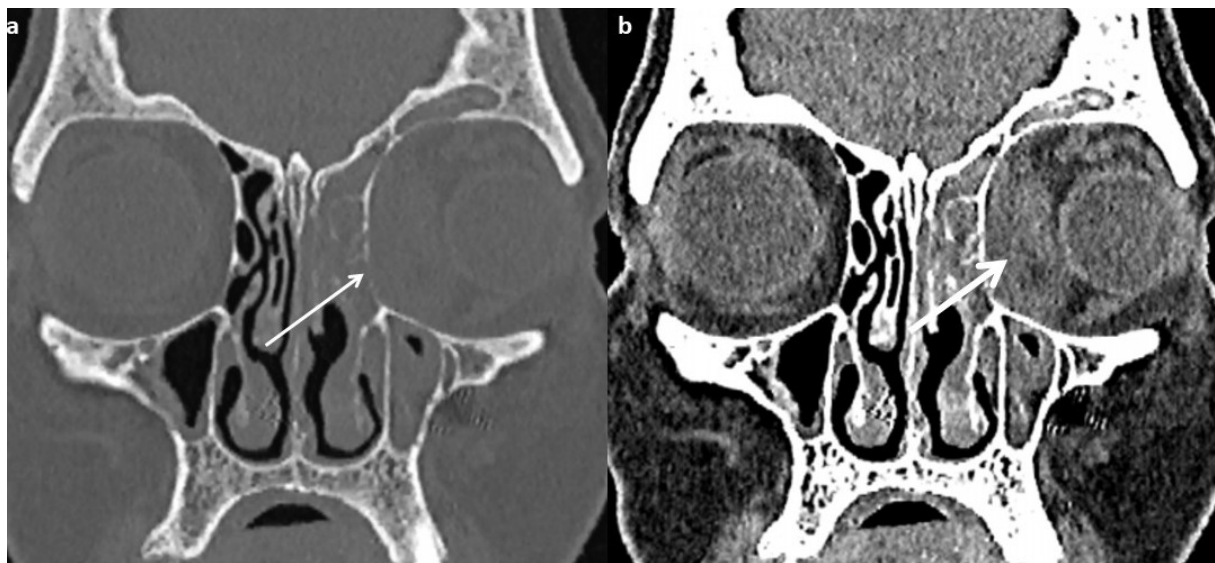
Coronal reformatted CT in (a) bone and (b) soft tissue window reveals thinning of ethmoid air cells and lamina papyracea (thin arrow). There is a soft tissue lesion in the left ethmoid air cells as well as in the medial aspect of the left orbit with thickening of the medial rectus muscle and displacement of globe laterally (thick arrow).
